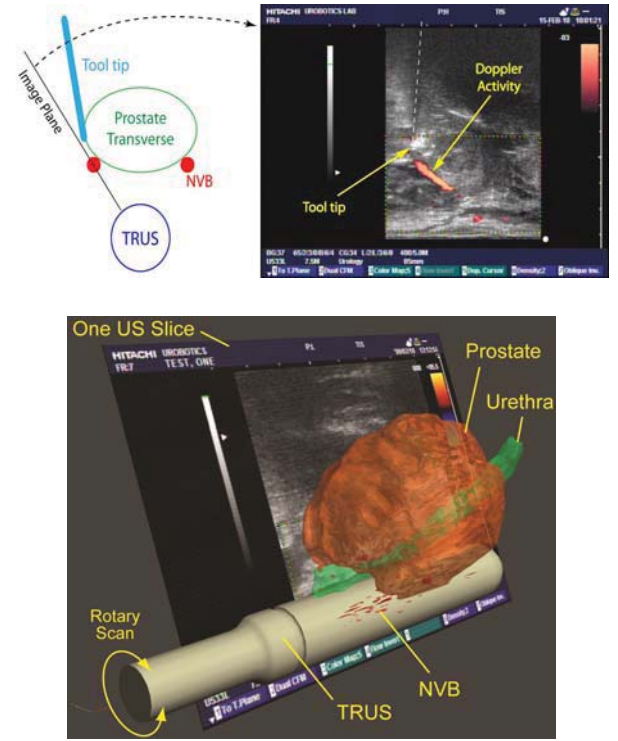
Intra-operative ultrasound image of prostate and adjacent Doppler activity during T-RALP and postoperative 3D reconstruction
